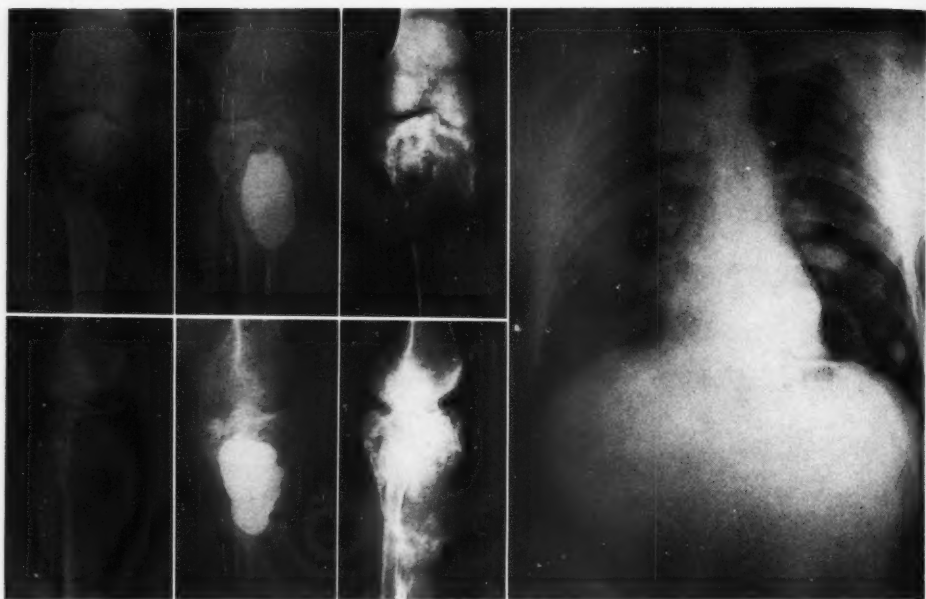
Case 10: Giant-cell tumor of right upper tibia. In 1925, three curettements and filling of bony cavity with bismuth paste. From 1926-1928 roentgen therapy. In 1932 accident with fracture at site of tumor, followed by sarcomatous degeneration. Patient died in 1933.
